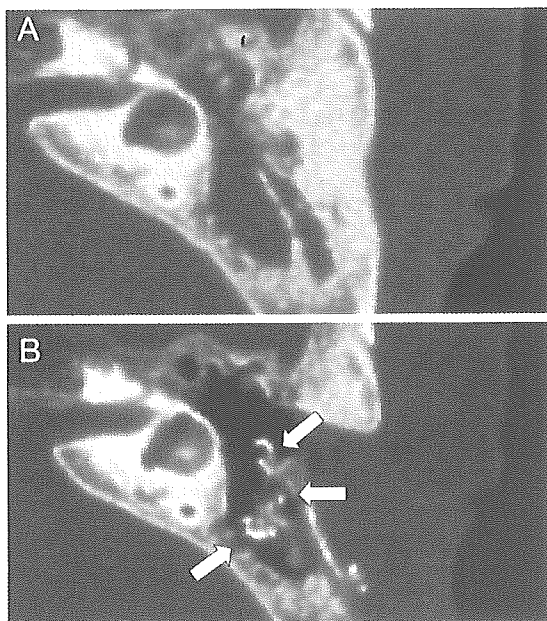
Computed tomography scan images of case 2, before and after surgery. (A) There is no aeration in the mastoid cavity before the operation. (B) Six months after the second-stage operation, aeration is recovered, and the pneumatic air cells are regenerated by the three-dimensional hydroxy apatite (arrows).
